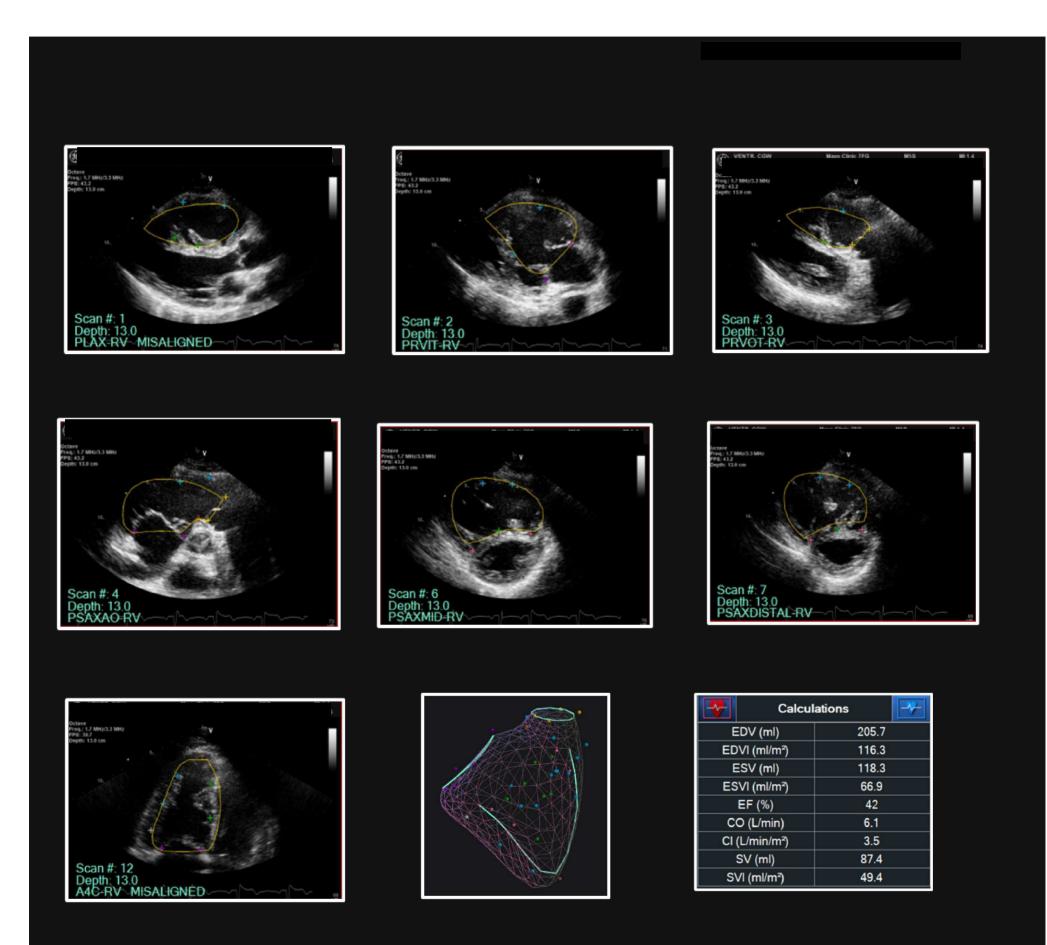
Patient Case 2 with views, 3D model, and calculations for Right Ventricle. (A) RV Parasternal Long Axis, (B) Parasternal Right Ventricular Inflow Tract, (C) Parasternal Short Axis Apric Outflow (F) Parasternal Short Axis Mid. (F) Parasternal Short Axis Distal. (C) Aprical A
